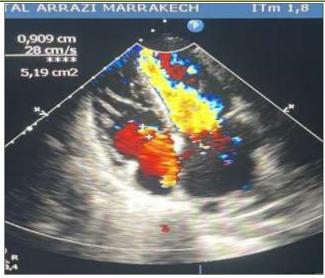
Transthoracic echocardiography; 4 chamber view showing Severe tricuspid regurgitation (vena contracta 9 mm, systolic regurgitant orifice 51 mm²)
